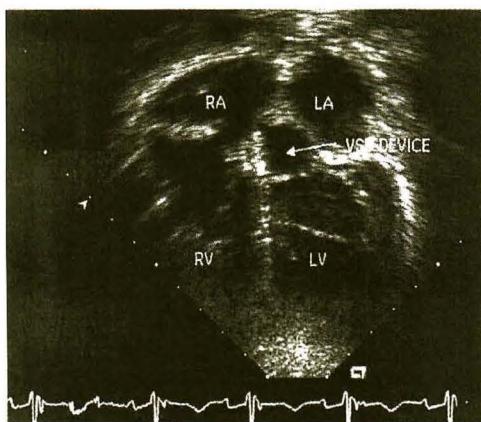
Echocardiography picture (four chambers view) showing VSD device in position.
